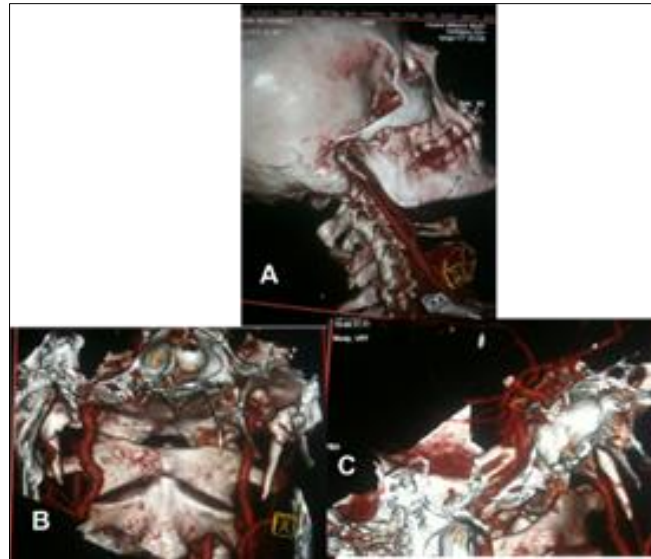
(A) Three-dimensional CT reconstruction showing the elongated right and left elongated styloid process. (B and C) coronal view and sagittal 3D CT scan reconstruction. Elongated styloid process (Eagle Syndrome).
